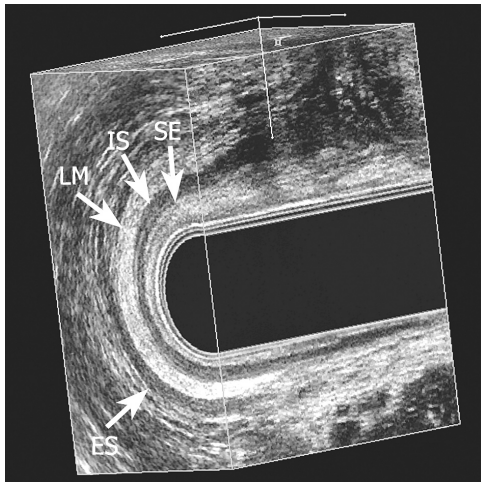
Three-dimensional endoanal ultrasonography, lateral view, from just below the mid-anal canal to above the puborectal muscle obtained from a 60-years-old man demonstrating normal anatomy of the four-layer structure of the sphincter complex. The top of the figure is anterior. SE = subepithelial tissues, IS = internal anal sphincter, LM = longitudinal muscle, ES = external anal sphincter
